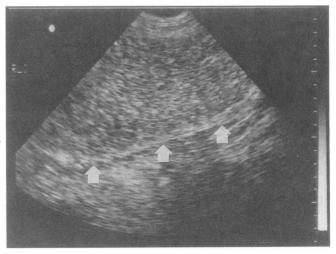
Ultrasonogram of large bowel obstruction (3.5 MHz). Dilated ascending colon was delineated as distended bowel filled with spot echoes. Because all the visualized large bowel loops are filled with solids, they may not be identified as readily as fluid-filled small bowel loops. The dilated colon is located above the filled arrows.
